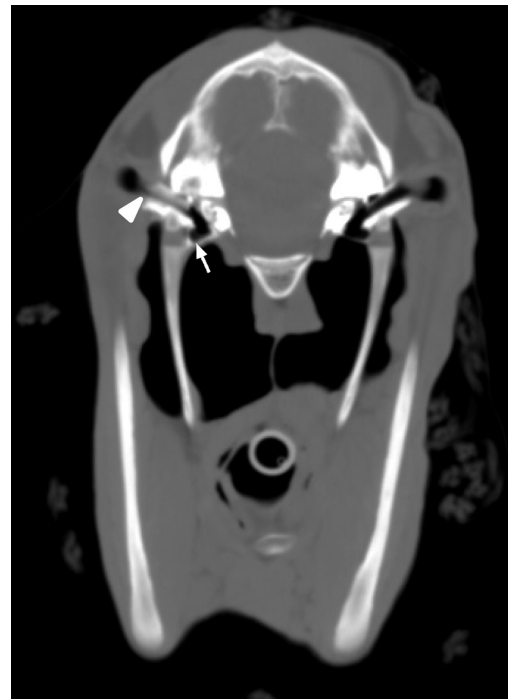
Computer tomographic (CT) image of the head. A cross-sectional view of the stylohyoid region reveals bony fusion of the joint (arrow) and constriction of the external ear canal (arrowhead).
